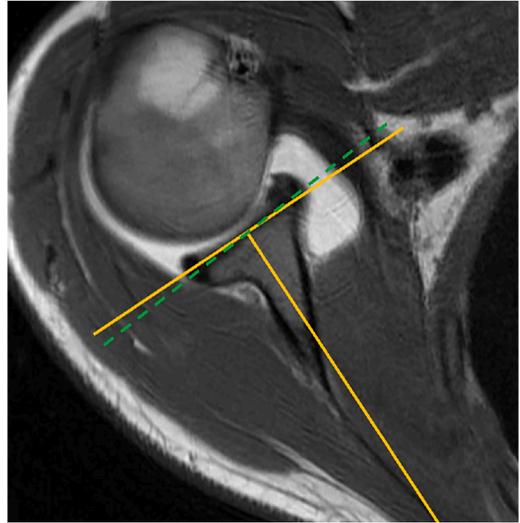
Axial MRI showing measurement of glenoid retroversion using the Friedman method. The dashed line represents the axis of anterior and posterior glenoid rims. The angle between the dashed line and the line perpendicular to the scapular body axis represents the degree of retroversion.
